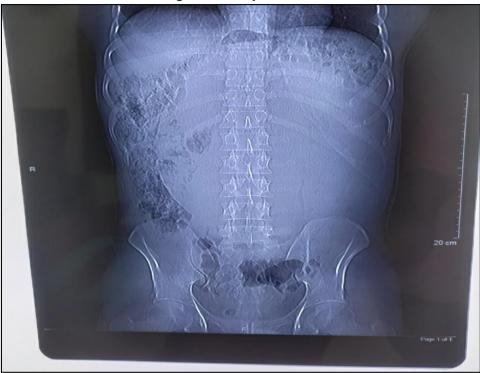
X-ray abdomen showed large soft tissue density mass covering the left half of the abdomen, crossing the mid line and extending to
